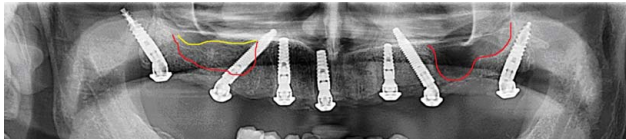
Panoramic radiograph following implant placement demonstrating the implants in the posteriors bilaterally in relation to the sinus floor prior to surgery (red) and level of graft placement (yellow).
